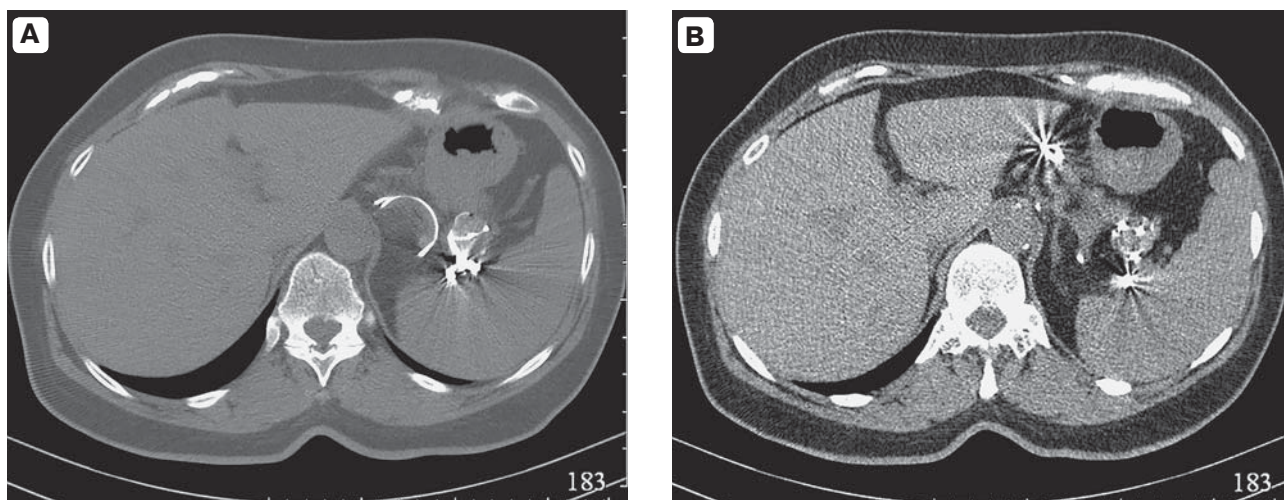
Abdominal computed tomography dated June 18, 2014. A, B – aneurysm of the splenic artery up to 26 mm in diameter with multiple lumpy calcifications and metal coils in the aneurysmal cavity and the SA.
